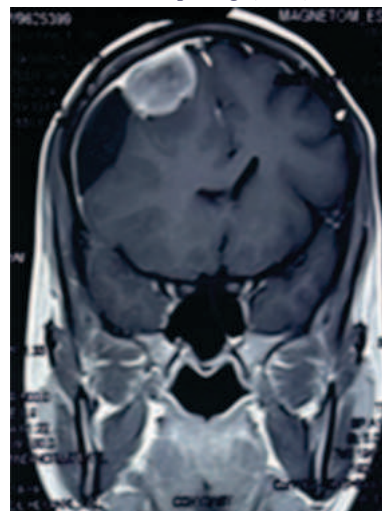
MRI T1+ Contrast Pre-op Image(coronal)
